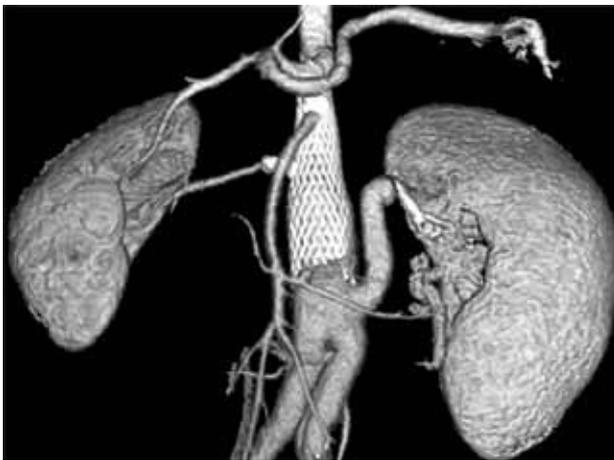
Computed tomographic angiography of the abdominal aorta and its main branches 36 months after the procedure reveals two deployed stents through the abdominal aorta and right renal artery, with no restenosis within the stents, no occlusion of abdominal aorta branches, nor any other related complications.
